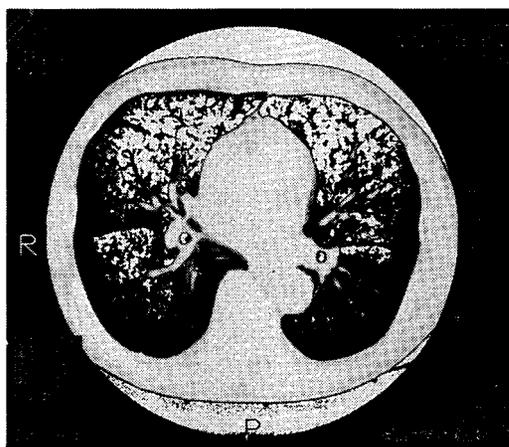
Low attenuation area (LAA) of the lung < -950 HU on high resolution CT in patients with asthma (71 years old, male, smoker)(maximal %LAA, 33.7%)
